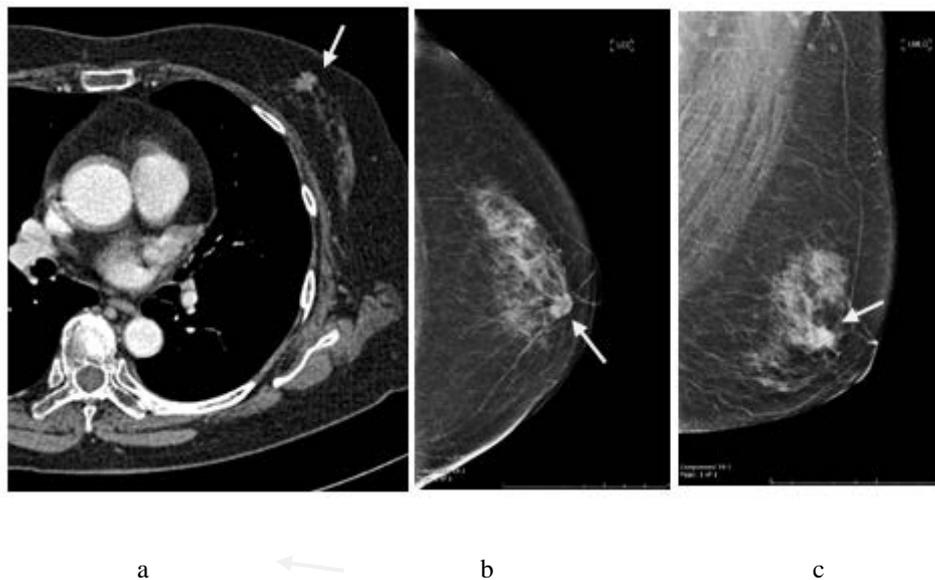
(a) Axial contrast enhanced CT showed left breast mass with irregular margin (arrow), (b) and (c) Mammography CC and MLO views showed irregular hyperdense mass with indistinct margin at subareolar region of left breast (arrow).
